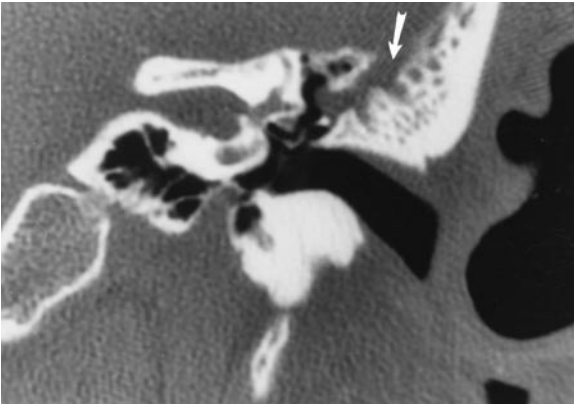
a Herniation of arachnoid granulation (arrow) through the roof of ethmoid responsible for cerebrospinal fluid rhinorrhea. b Metrizamide contrast CT of patient in a demonstrates continuity of the subarachnoid space with the arachnoid granulation (arrow)
